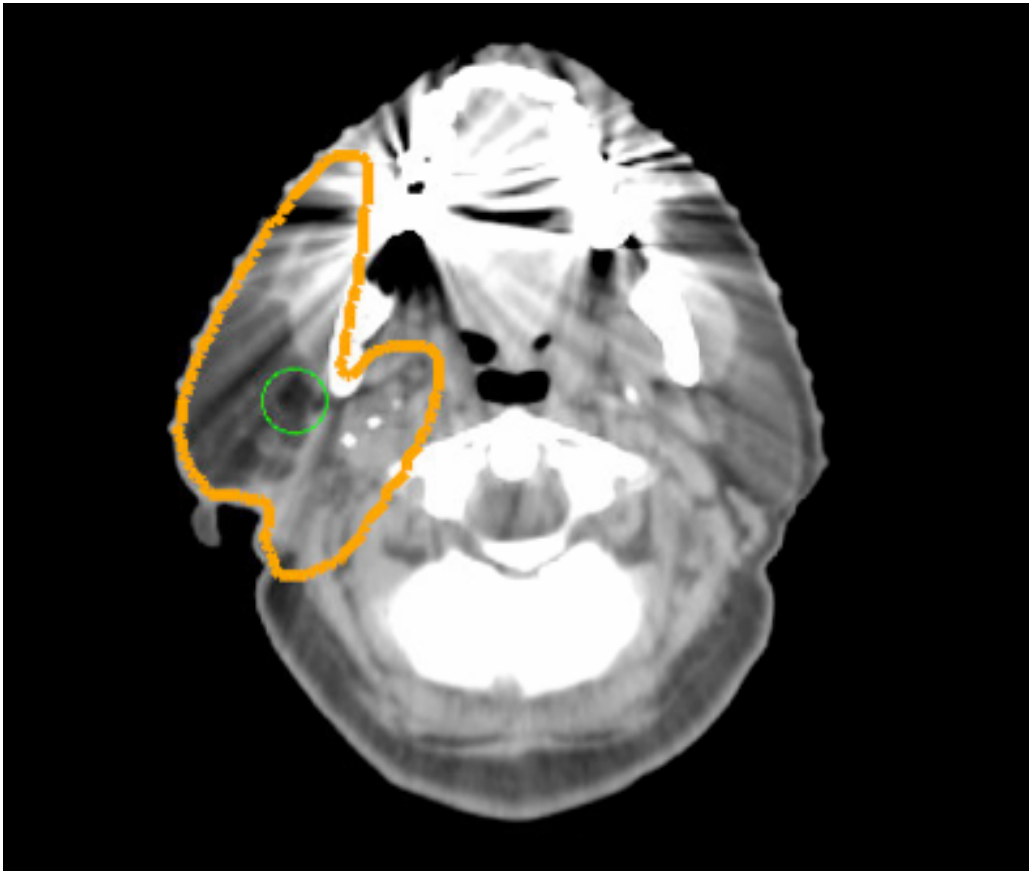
This is a slice of a patient CT scan that shows significant streaking artifacts. This patient was an excellent candidate for this project, as they have isodose lines and PTVs within the vicinity of the dental implants.
